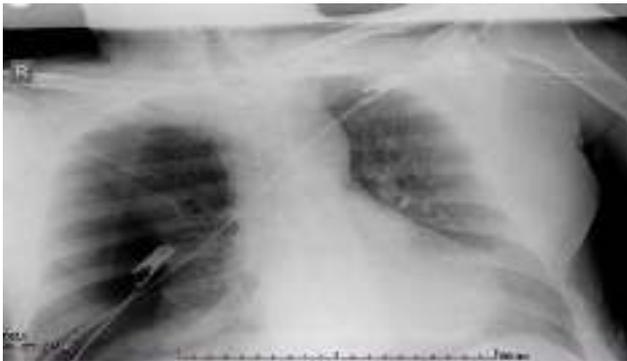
(patient's chest X-Ray first taken)
